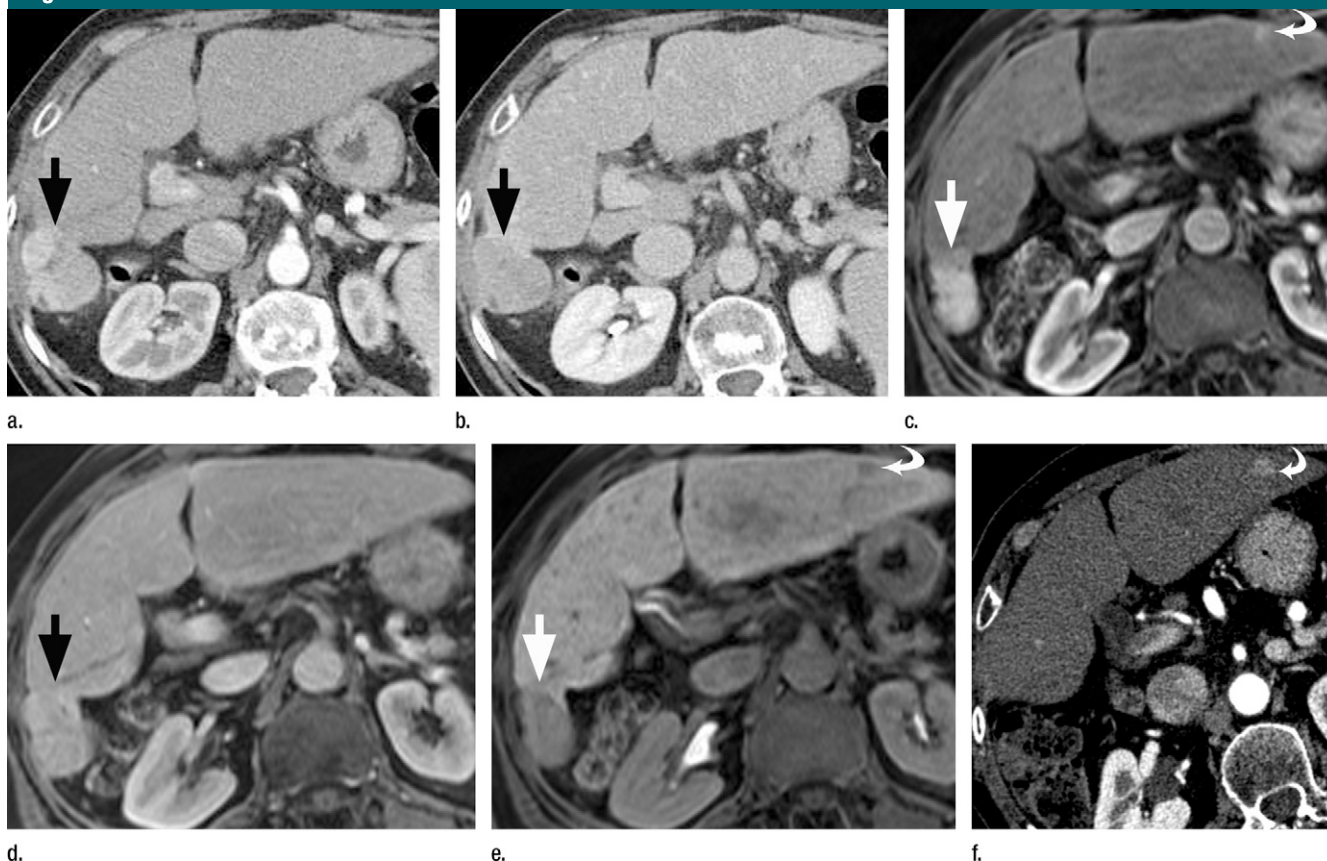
Images in a 73-year-old woman with cryptogenic cirrhosis (Child-Pugh class A) and two HCCs. (a) Transverse contrast-enhanced multidetector CT scan obtained during the hepatic arterial phase demonstrates a 4-cm, subcapsular, hyperattenuating lesion (arrow) in the right lobe of the liver. (b) Corresponding multidetector CT scan obtained during the delayed phase shows that the lesion (arrow) is hypoattenuating to the adjacent hepatic parenchyma (washout sign). (c, d) T1-weighted three-dimensional spoiled GRE gadoxetate disodium-enhanced MR images obtained with fat saturation and VIBE during the (c) hepatic arterial and (d) delayed phases. The enhancement pattern of the lesion (straight arrow) is similar to that seen at multidetector CT. A second high-signal-intensity lesion (curved arrow in c) measuring 1 cm was identified only during the hepatic arterial phase. (e) Corresponding MR image obtained during the liver-specific hepatobiliary phase, 20 minutes after contrast medium administration. Both lesions (arrows) are markedly hypointense to the highly enhanced background liver, a finding consistent with malignancy. (f) Multidetector CT scan obtained at 6-month follow-up shows resection of the larger lesion and a substantial interval increase (>30%) in the size of the smaller lesion (curved arrow). Biopsy of the smaller lesion was diagnostic of HCC.
